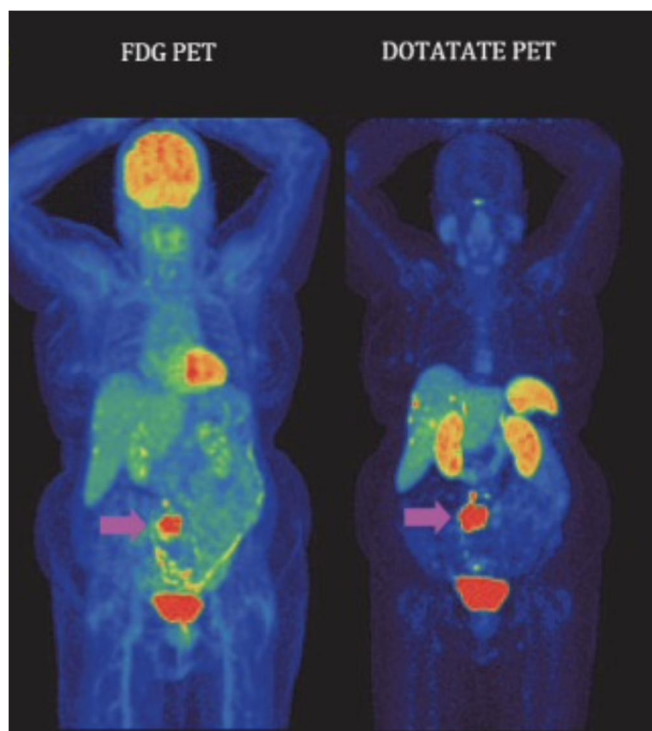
Example of the full body scan of FDG PET and Ga-68 PET/CT (Aslani et al, 2014)
